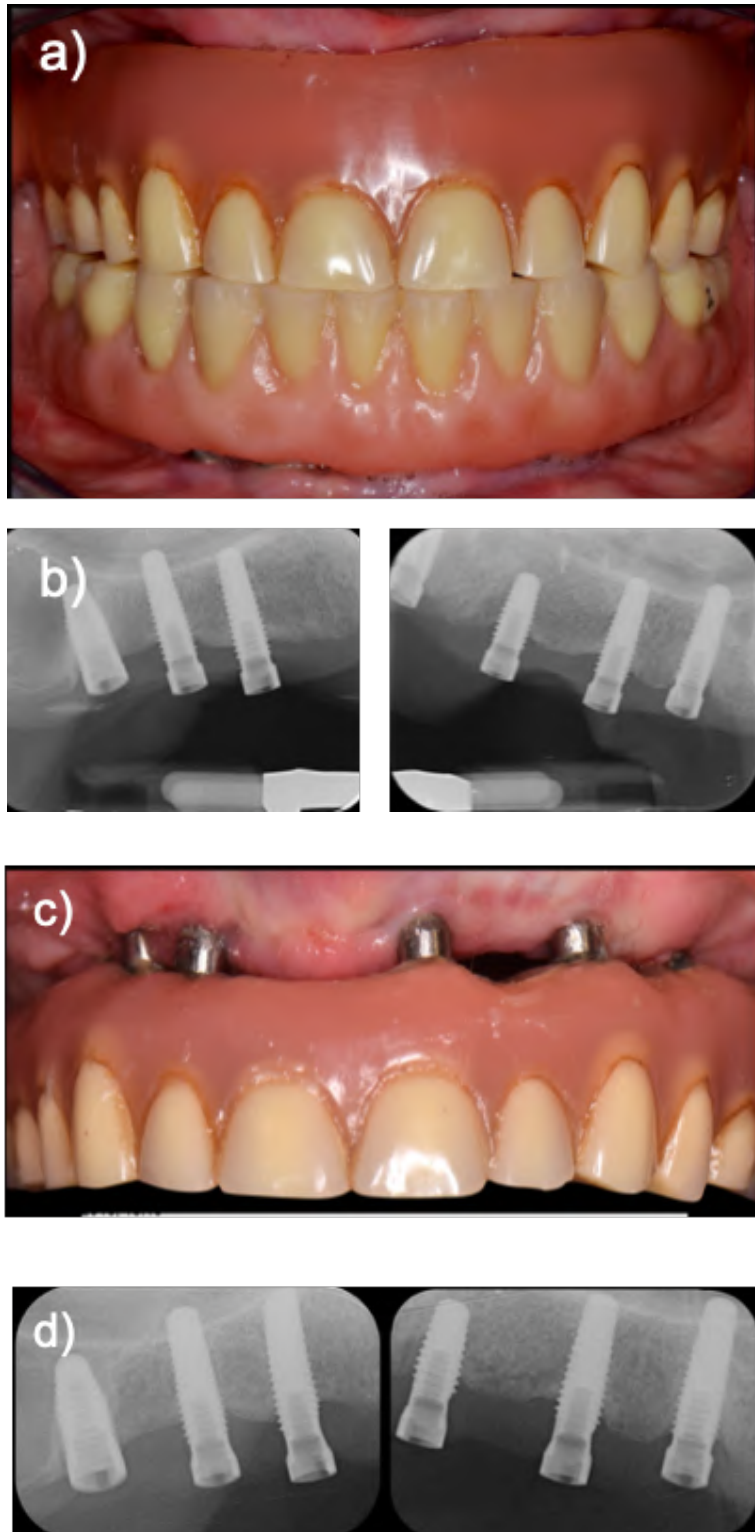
Initial and 15-month follow-up of full-arch PI case. a) Initial poor prosthesis design; b) Initial apical x-rays showing bone loss; c) 15 months after resective surgery with improved prosthetic design and soft tissue healing; d) Apical x-rays 15 months after resective surgery. Case treated in the Implant Maintenance Unit of the Master degree program in Oral Surgery and Implantology of the Universitat de Barcelona.
